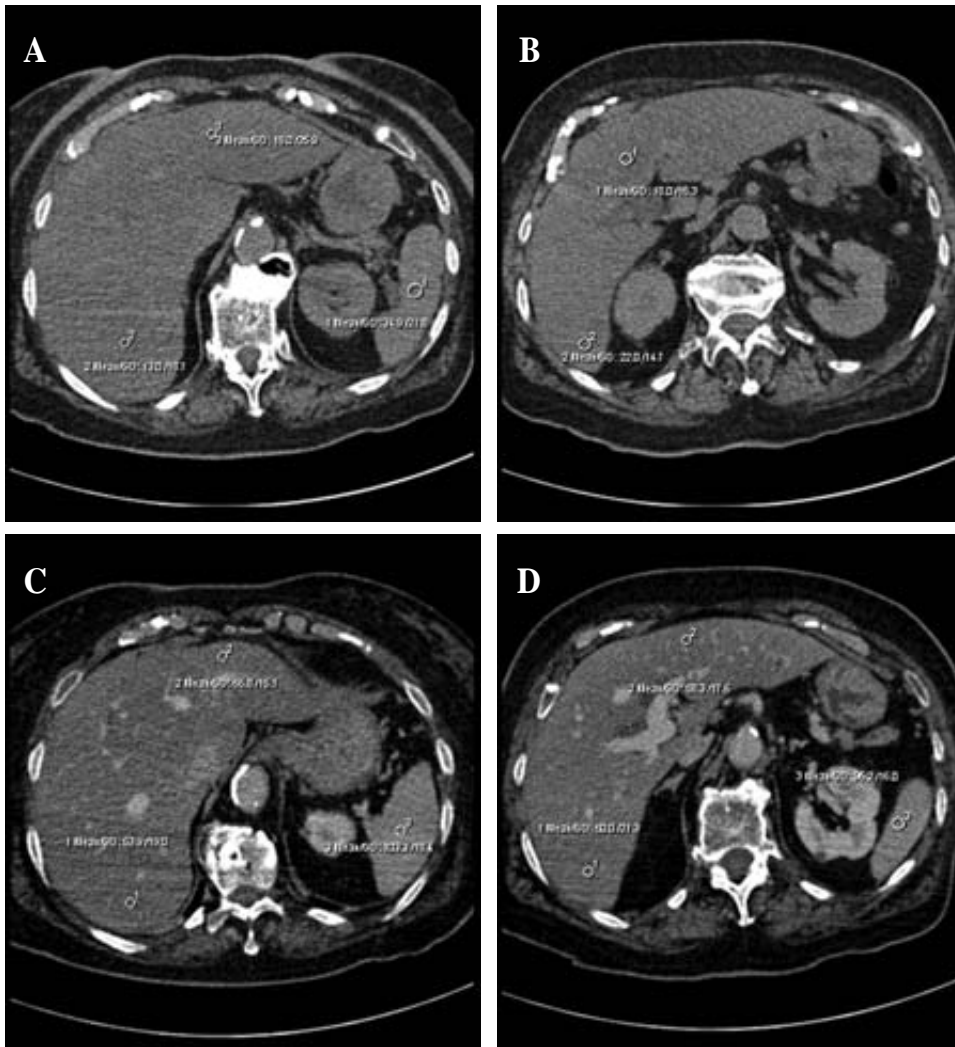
Severe hepatic steatosis. A–B, Unenhanced CT. There is a difference greater than 10 HU between the attenuation values of the liver (13–18 HU) and the spleen (31 HU). The attenuation of the liver parenchyma is also 40 HU lower than the normal value, which is sufficient to allow a diagnosis of grade II steatosis. C–D, Enhanced CT in the portal phase. There is less enhancement of the liver parenchyma (53 HU) than of the hepatic vessels and the spleen (103 HU). Again, there is a difference of more than 10 HU in the spleen–liver attenuation values.
